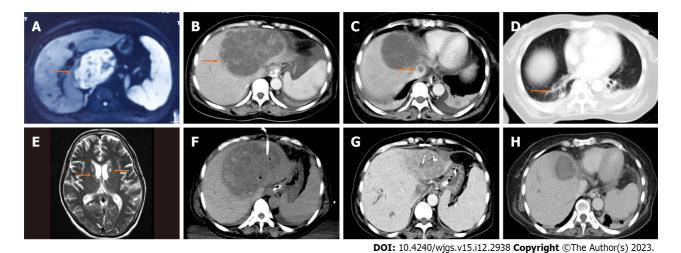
Magnetic resonance imaging or computed tomography images of the patient. A: A large heterogeneously cystic-solid mass was present in the left liver 1 mo prior to admission; B: An area of abnormal attenuation measuring 125 mm × 97 mm in the left lobe of the liver; C: Thrombus detected in the inferior vena cava by abdominal enhanced computed tomography (CT); D: Small patchy infiltrates identified in both lungs; E: Bilateral multiple T2 hyperintensities detected in the basal ganglia and subcortical white matter in the brain magnetic resonance imaging; F: Emergency ultrasound-guided percutaneous drainage of liver abscess was performed when the patient's condition deteriorated; G: The size of liver abscess markedly decreased in the reexamination of abdominal CT; H: Inferior vena
